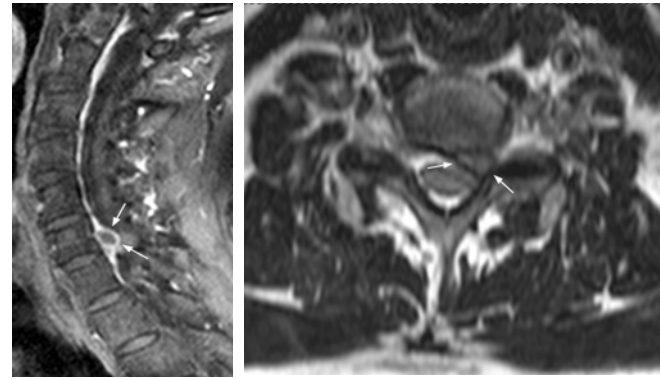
Left: Peripheral enhancement on contrast enhanced T1-weighted sagittal image showing sequestration (arrow). Right: T2-weighted axial image shows the lesion isointense with the nucleus pulposus and spinal cord (arrow). There is obliteration of subarachnoid space, left mediolateral cord compression and narrowing of left neural foramen.
